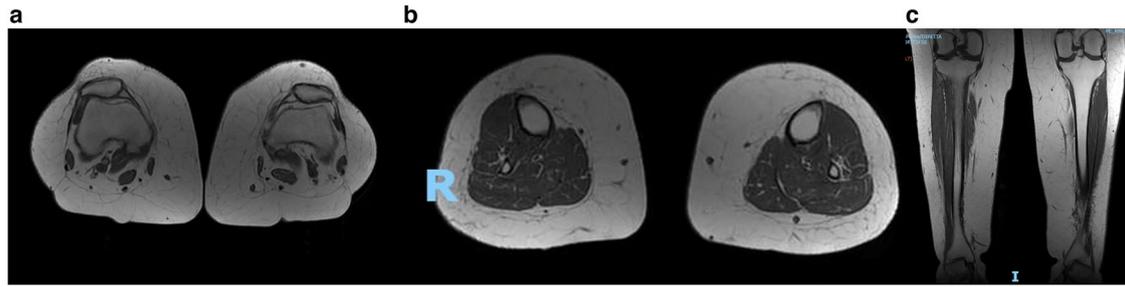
MRI features of lower-limb lipedema. Magnetic resonance T1-weighted images of the a knee joint line axial view b mid-section of the lower legs axial view and c lower leg coronal view showing diffuse thickening with volumetric increase of the SAT in the legs, with some areas of mild edema and fluid layers, more evident in the knee joint line.
